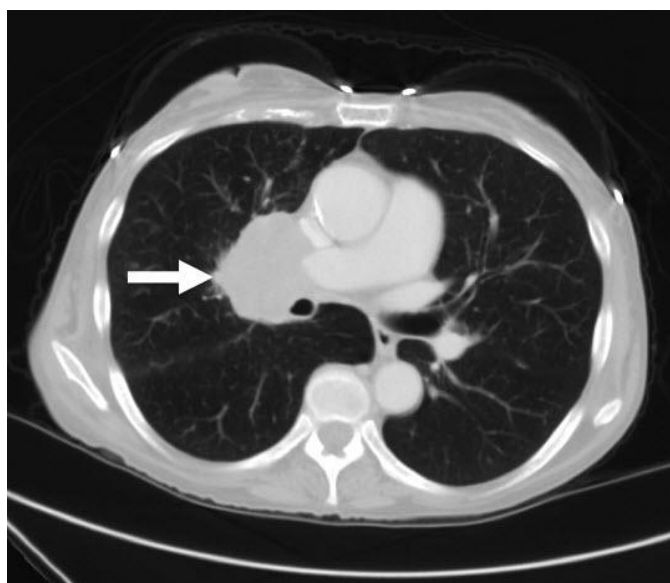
58 year old female with Bazex syndrome had a 2 year history of a hyperpigmented rash and presented for CT after an abnormal chest radiograph. Contrast enhanced axial CT images of the chest confirms the presence of large right perihilar soft tissue mass. (protocol: 250 mAs, 120 kvp, 5mm slice thickness, venous phase, 100 cc isoview-300.)
